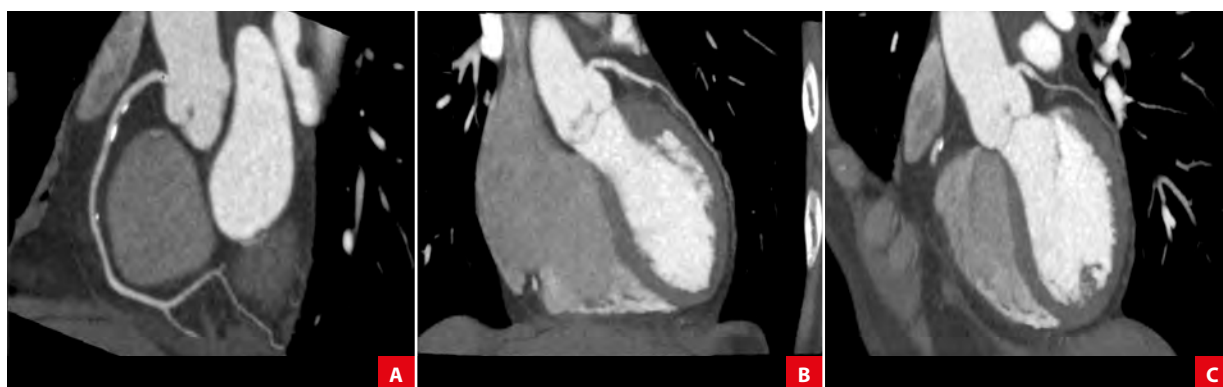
Coronary CT angiography showing a dominant right coronary artery (A), left anterior descending coronary artery (LAD) (B) and left circumflex (C). Although no evidence of significant stenosis was observed, several atherosclerotic plaques were identified. In addition, the distal part of the LAD was relatively small and difficult to evaluate.
